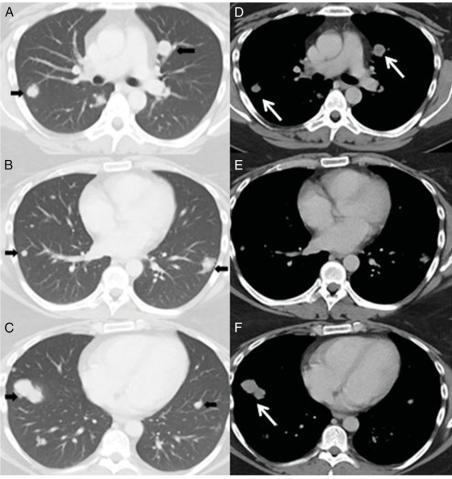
A-C, Chest CT scans without contrast revealed multiple nodular lesions in all lobes of both lungs, variably distributed from the central zone to the periphery (black arrows). The nodules varied in size from 1.1 to 2.0 cm, having sharp to mildly irregular margins. The majority of these nodules are subpleural and fissural in location, anatomically a perilymphatic distribution. D-F, Soft tissue window at the same level demonstrates mildly heterogeneous soft tissue density (white arrows). No lymphadenopathy. No pleural or pericardial effusions. G, Some lesions had an associated "feeding vessel sign," correlating with a perivascular distribution seen on pathology (white arrow).
